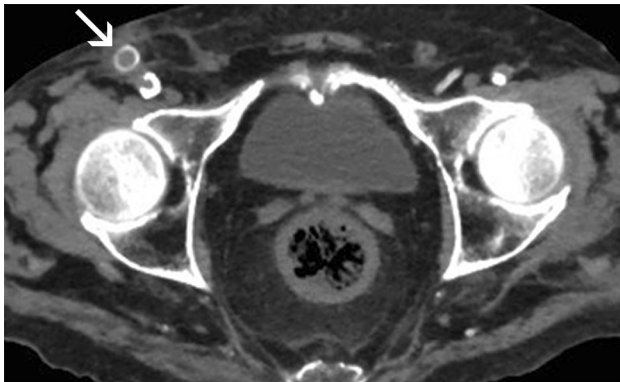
A 70-year-old male patient presented with acute gastrointestinal bleeding, referred for angiography and embolization of the bleeder. Review of the previous CT showed a *right* femoral artery graft (*arrow*). A *left* femoral artery access was selected
